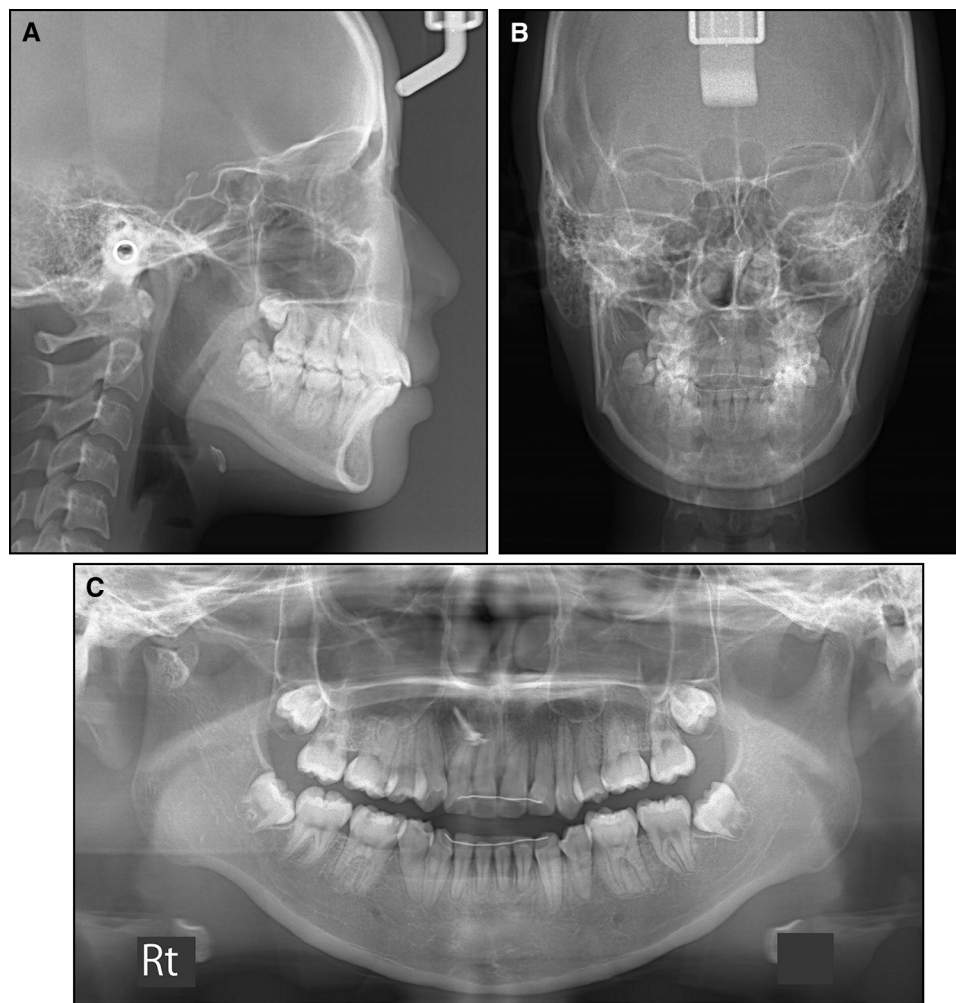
Posttreatment radiographs: A, lateral cephalogram; B, posteroanterior cephalogram; C, panoramic radiograph.
